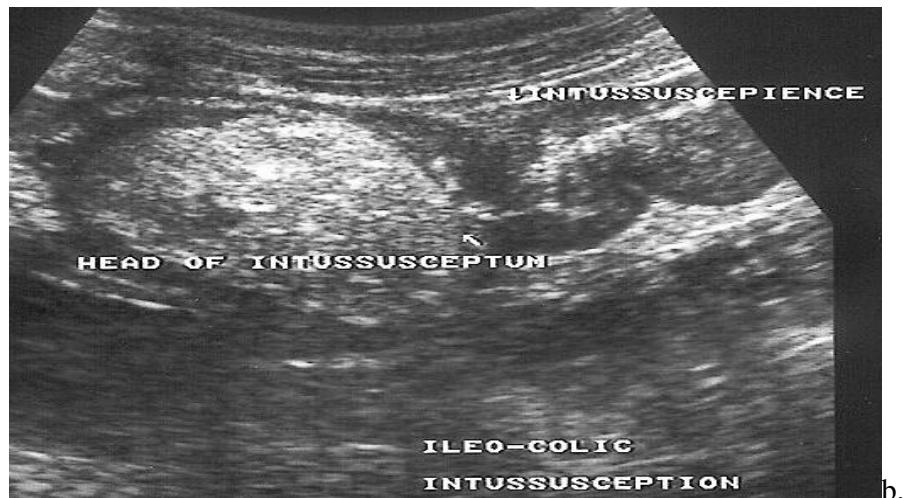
Sonogram showing the head of the intussusceptum within the intussuscipiens in an ileo-colic intussusception
